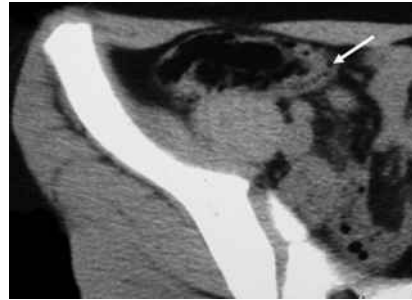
Axial CT image of the same patient shows a thickened appendix with intraluminal air inside (arrow) and no evidence of periappendiceal streakiness.
